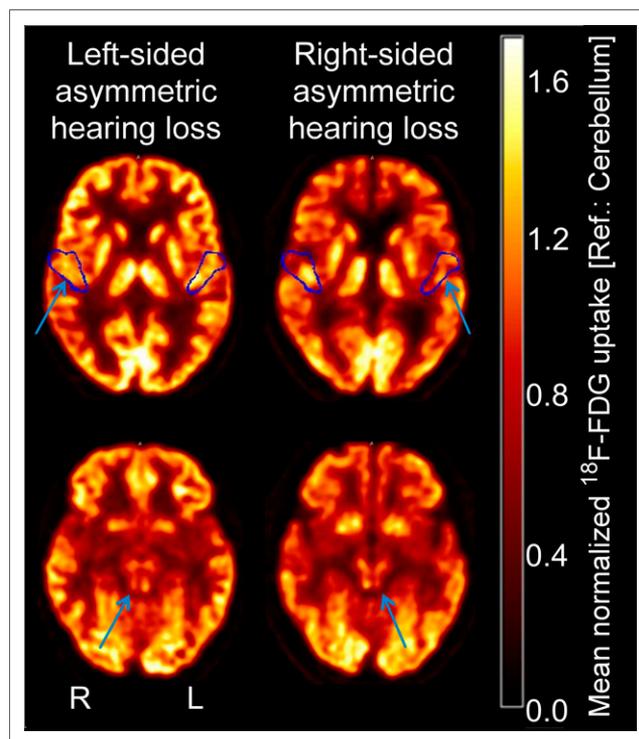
Axial ^{18}F -FDG PET scans at level of PAC (top, VOI outline in blue) and IC (bottom) in 2 representative patients with left-sided (left image) and right-sided (right image) AHL. Arrows indicate side of decreased metabolism.
